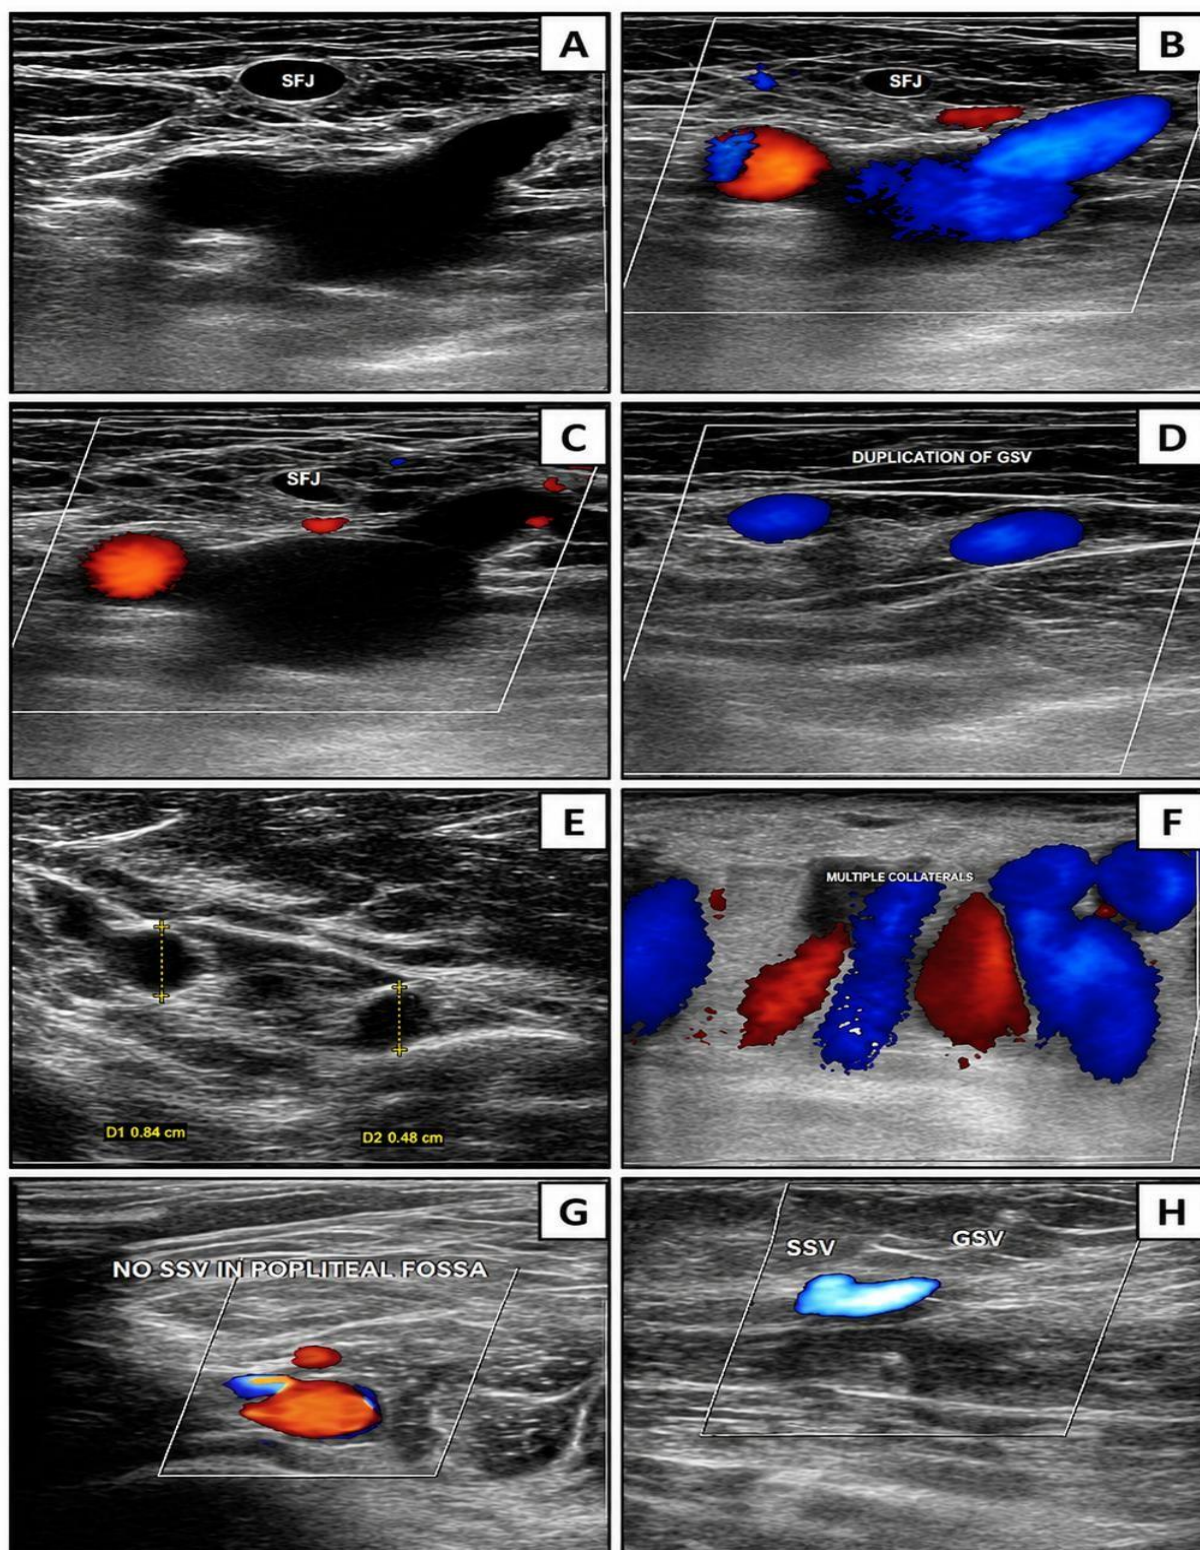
Ultrasonographic appearances of the superficial venous system: (A) Grayscale image of the saphenofemoral junction (SFJ); (B) Colour Doppler image of the saphenofemoral junction; (C) Colour Doppler demonstrating a competent saphenofemoral junction; (D) Colour Doppler image showing duplication of the great saphenous vein (GSV); (E) Grayscale image showing increased calibre of the great saphenous vein; (F) Colour Doppler image demonstrating multiple collateral veins along the course of the great saphenous vein; (G) Colour Doppler image showing absence of the saphenopopliteal junction (SPJ) with no small saphenous vein (SSV) identified in the popliteal fossa; (H) Colour Doppler image showing the small saphenous vein draining into the great saphenous vein at the medial aspect of the mid-leg.
